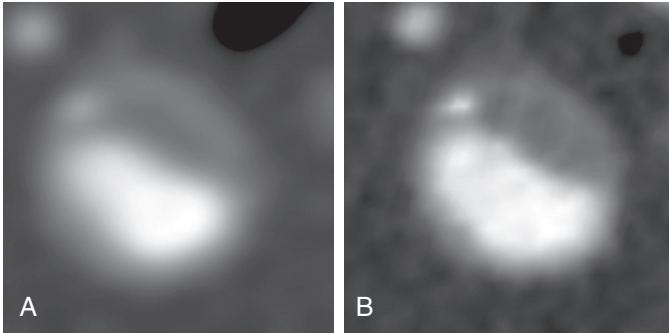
Thin cross section of coronary artery plaque as seen with standard-definition CT (detector width of 0.625 mm) (A) and high-definition CT (detector width of 0.312 mm) (B). High-definition CT may enable more accurate detection of plaque and grading of coronary stenosis but is investigational at present.
